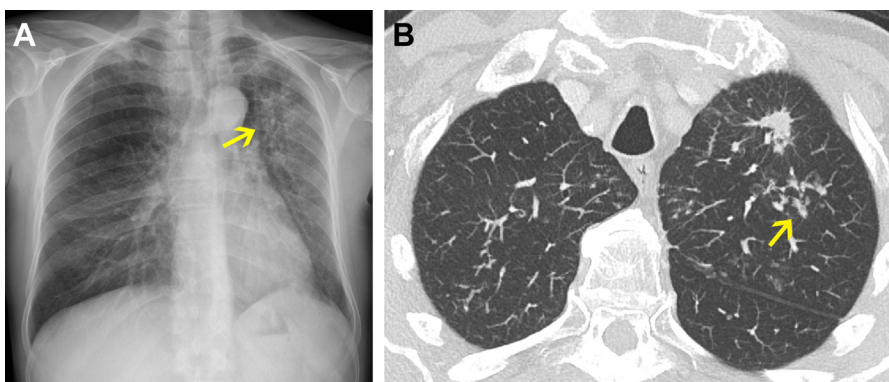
Mycobacterium avium*–intracellulare complex. (A) Posteroanterior chest radiograph shows an ill-defined left upper lobe opacity (arrow) with associated minimal collapse of the left upper lobe. (B) Axial CT image at the level of the left upper lobe shows a spiculated nodular opacity. Note the presence of a few tree-in-bud opacities nearby (arrow) representing NTM infection. The differential diagnosis and clinical concern were of a primary lung carcinoma.
